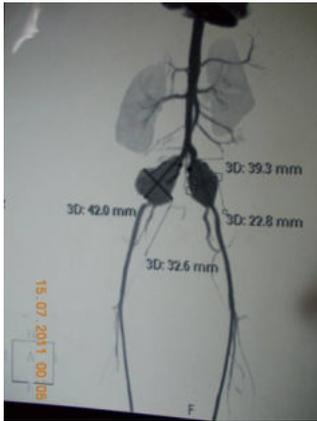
CT Angio of 3 months old male child.
